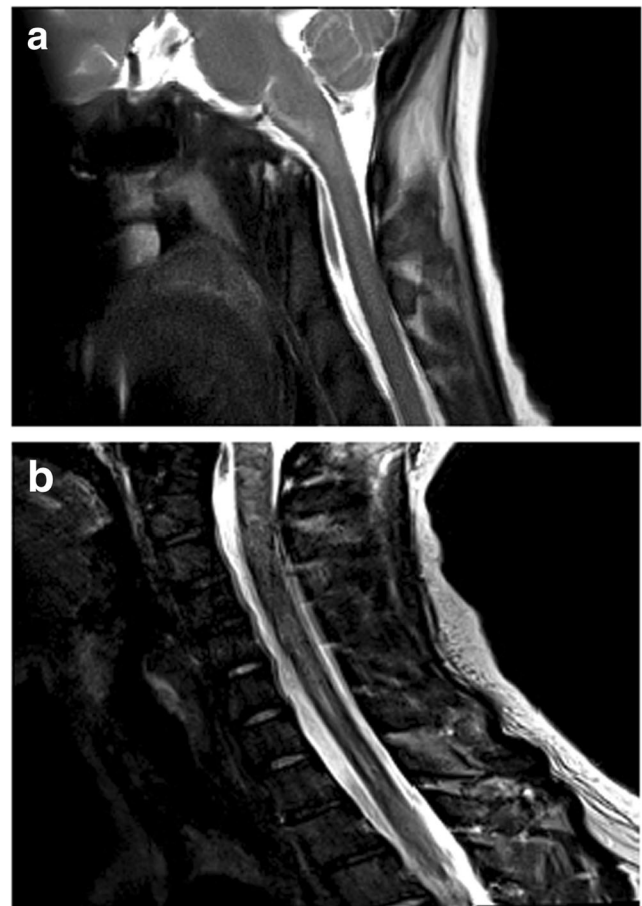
a Magnetic resonance imaging (MRI) T2-weighted sagittal section of the cervical spine showing hyperintensity of the anterior medulla. b MRI T2-weighted sagittal section of the cervical spine showing hyperintensity of the cervical and thoracic cord
